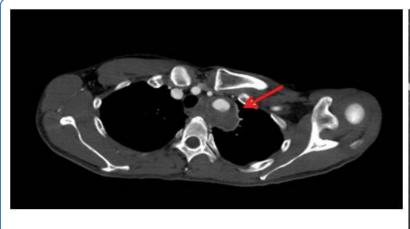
Enhanced CT image showing the aneurysm and occlusion of left subclavian artery (arrow).
